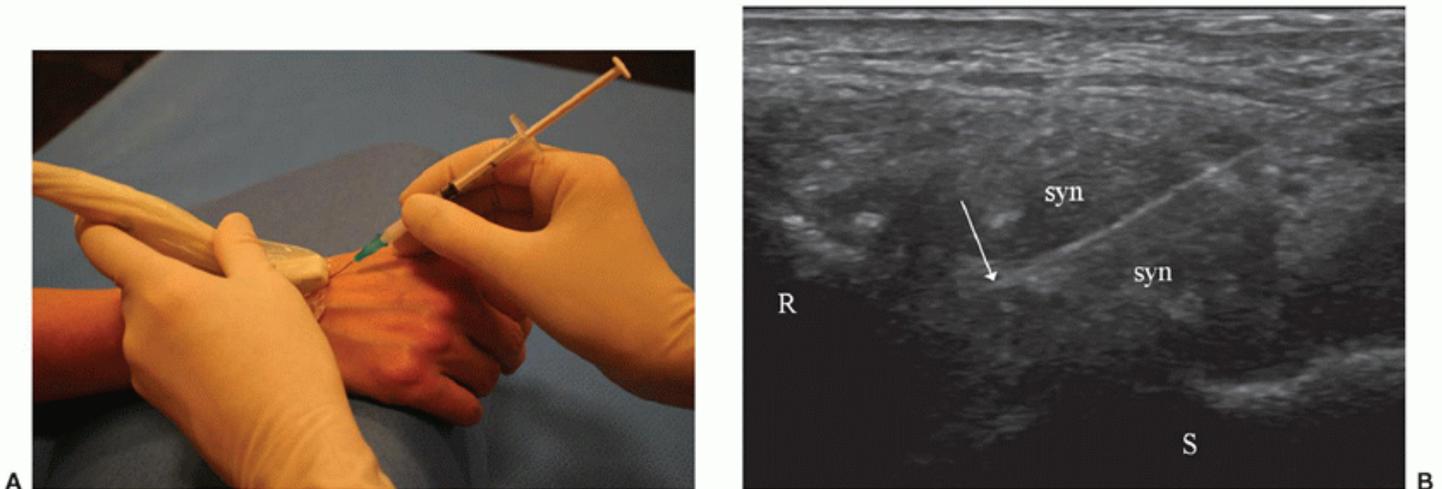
Ultrasound-guided injection in the dorsal recess of the radiocarpal joint with a longitudinal scan just distal to the Lister tubercle on the radius. A: Position of the transducer. B: Needle tip (arrow) in the radiocarpal recess enlarged by synovial hypertrophy (syn) in a patient with osteoarthritis. R, radius; S, scaphoid.
